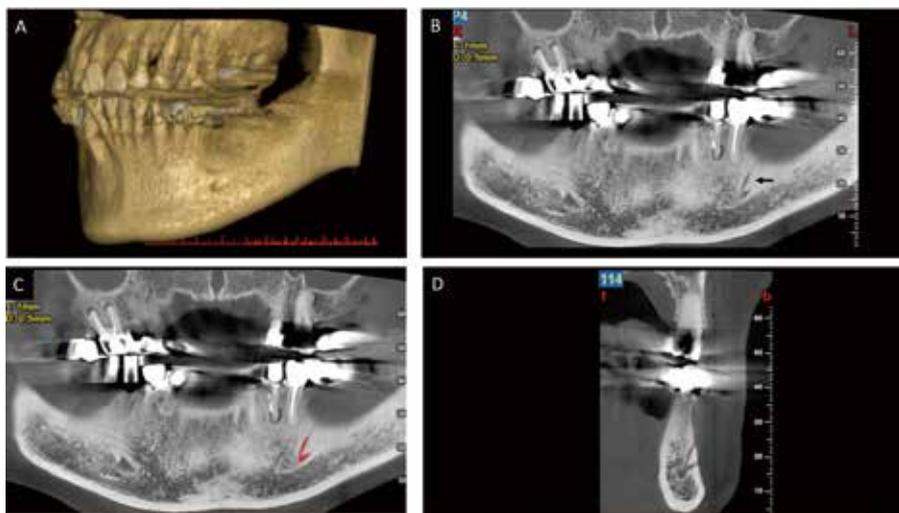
Cone-beam computed tomography analysis of Case 1 (A) Reconstructed 3D image showing 2 foramina at the apex of the first molar on the left side of the mandible. (B) Panoramic image revealing the branches of the mandibular canal (arrow). (C) Red line marking the branches of the mandibular canal on a panoramic image in the software analysis. (D) Cross-sectional image confirming the branches of the mandibular canal passing through the lateral wall of the mandible.
